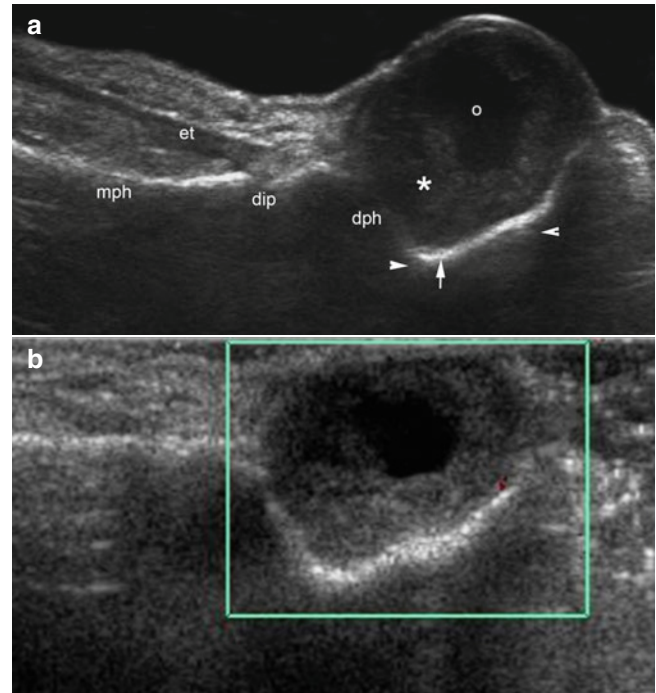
(a, b) Keratoacanthoma. (a) Grey scale ultrasound image (longitudinal view, left hallux) shows a mixed echogenicity mass that presents a hypoechoic rim (*) and anechoic center (o). This mass displaces the nail plates upward and produces scalloping of the bony margin of the distal phalanx (*arrowheads*). (b) Color Doppler ultrasound image (longitudinal view) shows hypovascularity within the mass. *Abbreviations:* nb nail bed, dph distal phalanx, dip distal interphalangeal joint, mph middle phalanx, et extensor tendon
